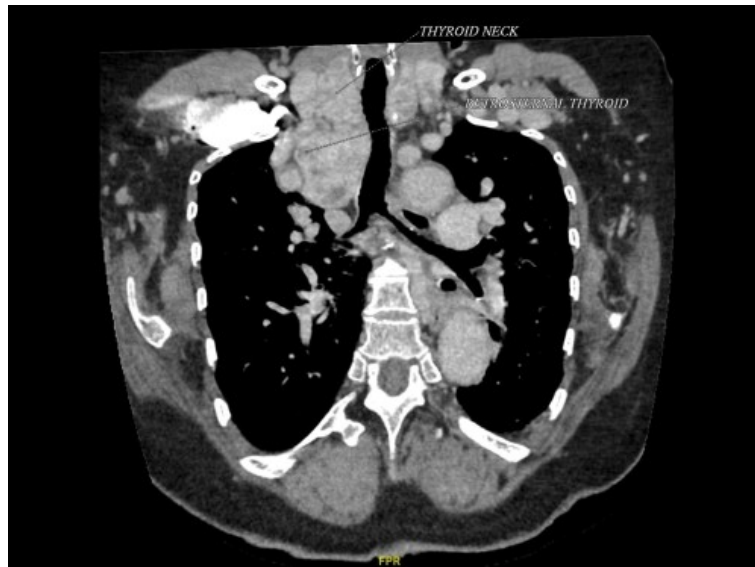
CT Thorax showing paratracheal extension of right lobe of thyroid reaching up to the inferior border of aortic arch
